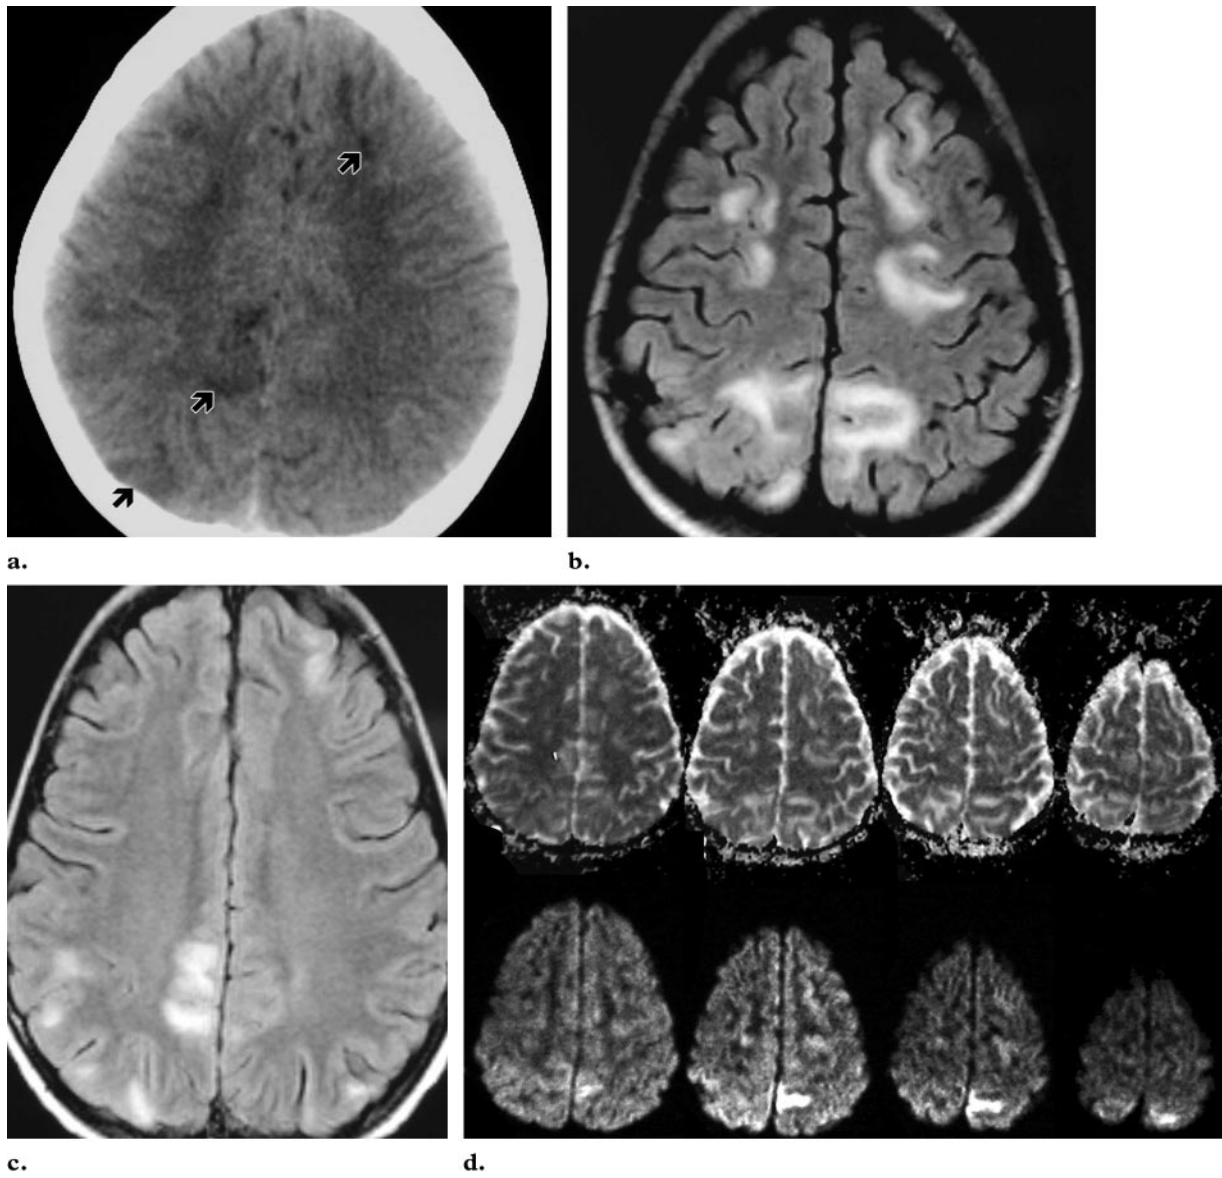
Reversible posterior leukoencephalopathy in a 12-year-old boy with ALL and a bone marrow transplant who presented with visual disturbances and seizures. The clinical symptoms coincided with arterial hypertension. (a) Axial CT scan shows hypoattenuating cortical-subcortical lesions in the parietal lobes (arrows). (b, c) Axial fluid-attenuated inversion-recovery MR images (b obtained at a lower level than c) show the lesions more clearly. (d) Axial isotropic diffusion-weighted MR images show an elevated apparent diffusion coefficient in regions with the corresponding signal intensity abnormality on T2-weighted images. The patient recovered from the neurologic symptoms after blood pressure was controlled, and follow-up MR imaging demonstrated complete resolution of the lesions.
